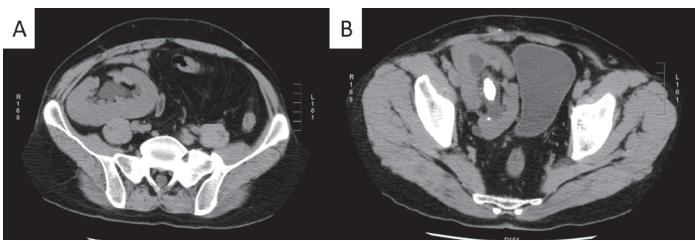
Two images of the same patient with a right pediatric en bloc renal transplant. A, The lateral kidney was malrotated, making access challenging. B, The medial kidney with a 2-cm renal pelvis stone that was amenable to right lower quadrant percutaneous access via ultrasound guidance.
